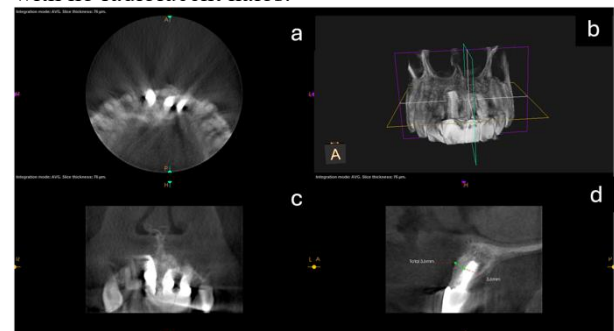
Twelve-month CBCT (eight-months functional loading) confirming long-term ridge preservation. (a) Axial slice documenting a 3.6 mm bucco-palatal ridge width (green calibre). (b) Volume-rendered view
